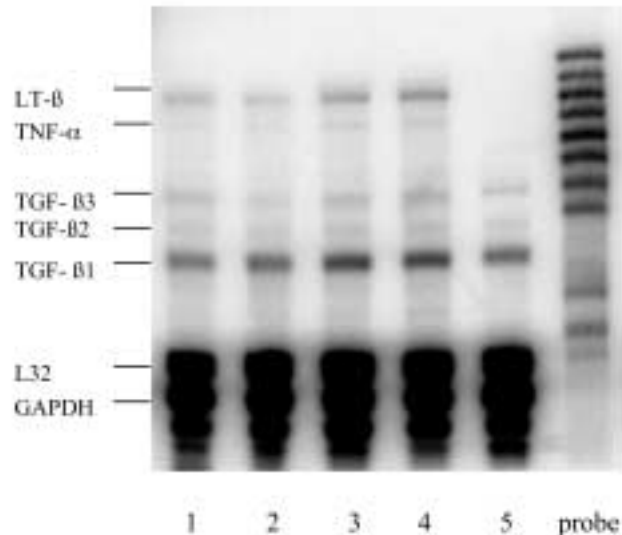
Representative RNase protection assays for cytokines and cytokine receptors. A. IL-1 β , IL-1Ra, L32 and GAPDH, and B. LT- β , TNF- α , TGF- β 1,2,3, L32, GAPDH. Samples 1 and 2 are RNA from bone biopsies following cryogenic μ -CT scanning. Samples 3 and 4 are RNA from bone biopsies that had not been scanned. Sample 5 is RNA from MG63 cells. Please note that LT- β is expressed in human bone but not in cultured osteosarcoma cells. In contrast, TGF- β isoforms are similarly expressed in bone and in cell culture. The L32 and GAPDH bands appear to be over exposed because of limitations of the printer. The intensity of these bands is well within the linear range of the phosphoimager used to measure their intensity.
